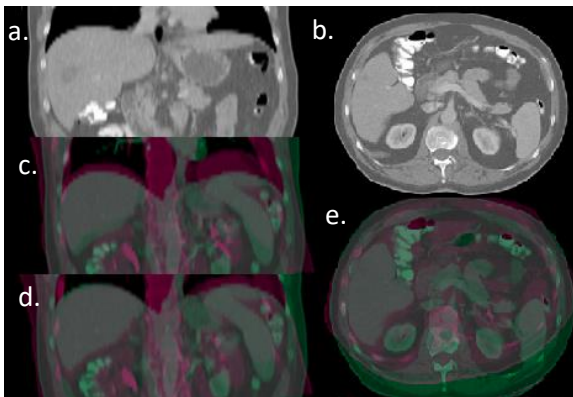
Rapid registration with PLANET[®] Dose. (a, b) Contrast-enhanced CT, coronal (a) and axial (b). Proposal for registration of contrast-enhanced CT+ CT of the PET and (c) final registration between contrast-enhanced CT+ CT after manual millimetric adjustment of the liver contour (d, e)
